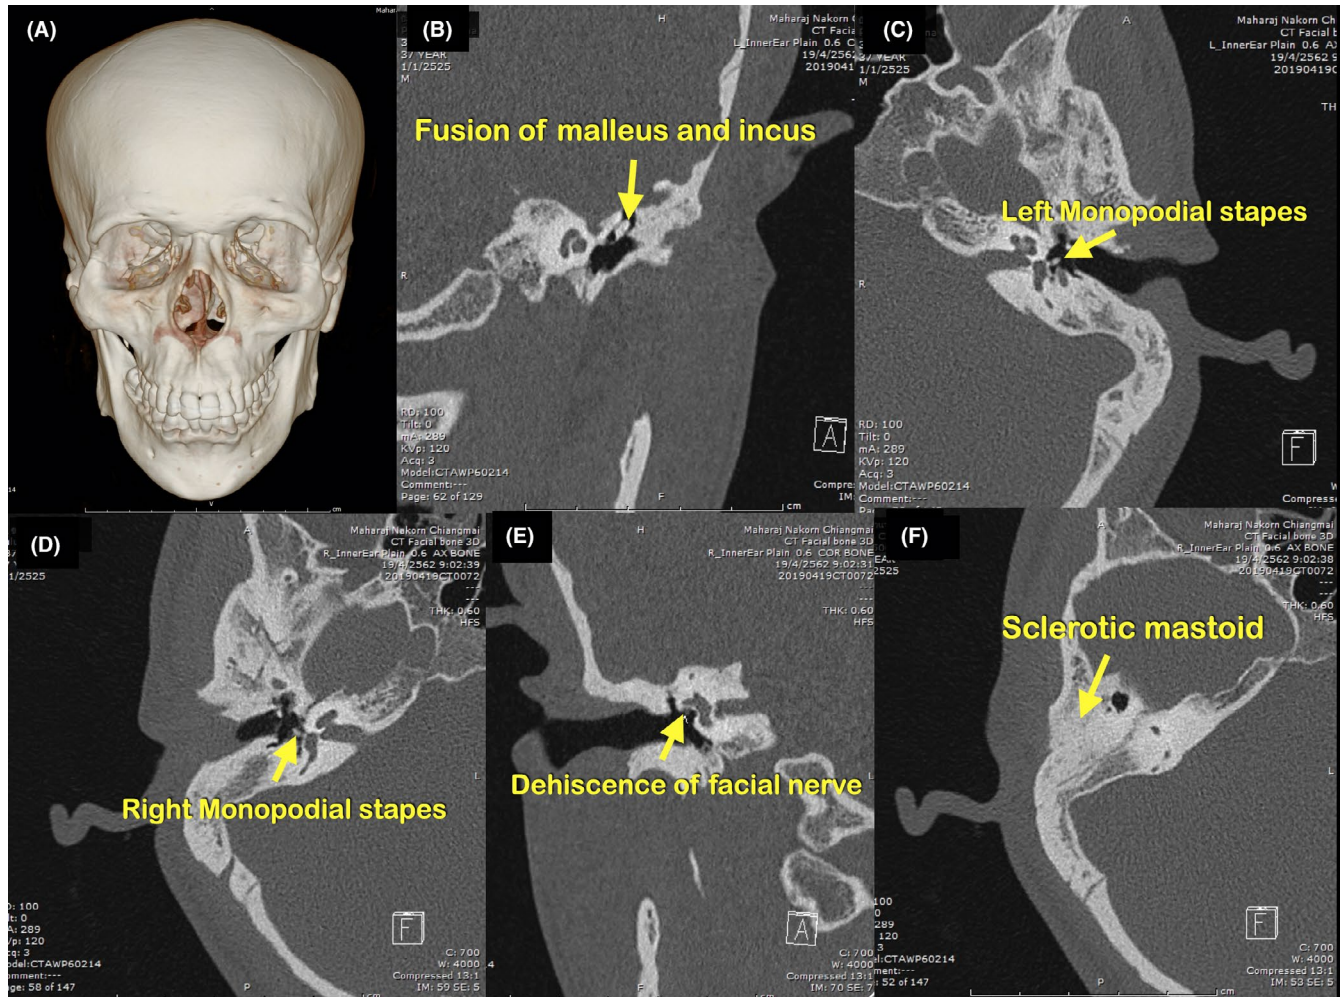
Computed tomograms of Patient II-2. (A) Unremarkable skull. (B) Fusion of right malleus and incus. (C) Monopodial stapes of left ear. (D) Monopodial stapes of right ear. (E) Dehiscence of tympanic part of right facial nerve. (F) Non-pneumatized mastoid air cells of right ear
